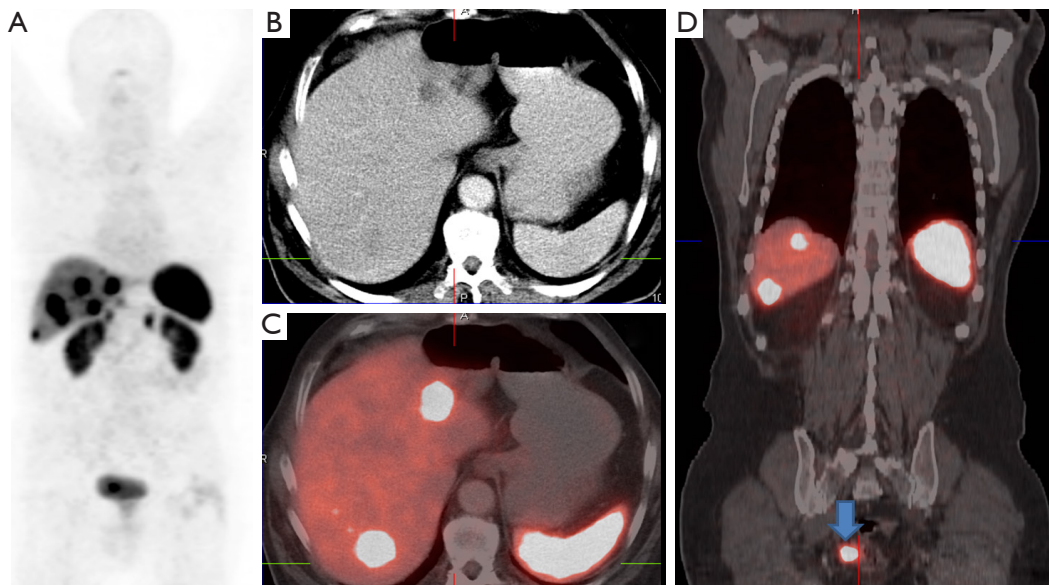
A 76-year-old patient with well-differentiated, non-functional NEN in the rectosigmoid junction (ENETS G1) with extensive SSTR positive bilobar liver metastasis demonstrated on Ga-68 SSTR PET/CT [(A) MIP image; (B) CECT and (C) fused transverse PET/CT], which also exhibited the receptor positive primary tumor [arrow in (D), fused coronal PET/CT]. The patient was treated with 2 cycles of peptide receptor radionuclide therapy (PRRT administering a total of 12.9 GBq Lutetium-177 DOTATATE and DOTATOC).
